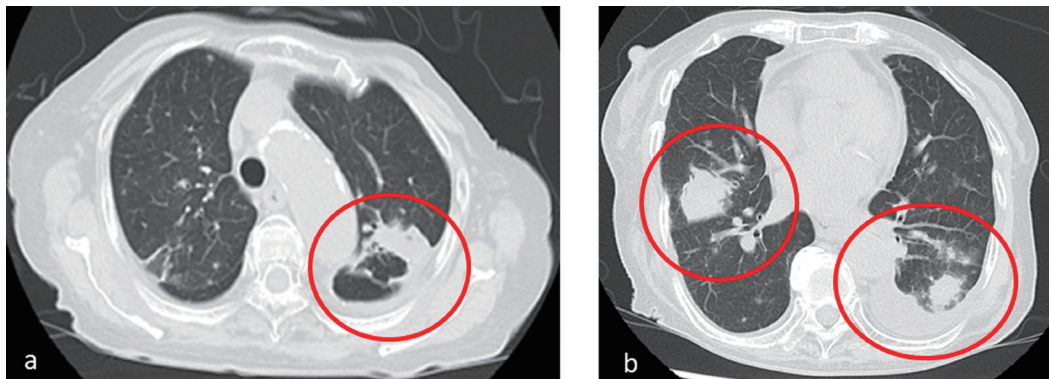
Chest computed tomography images at the development of tuberculosis. Red circles show new, active infiltrations of the lungs.
